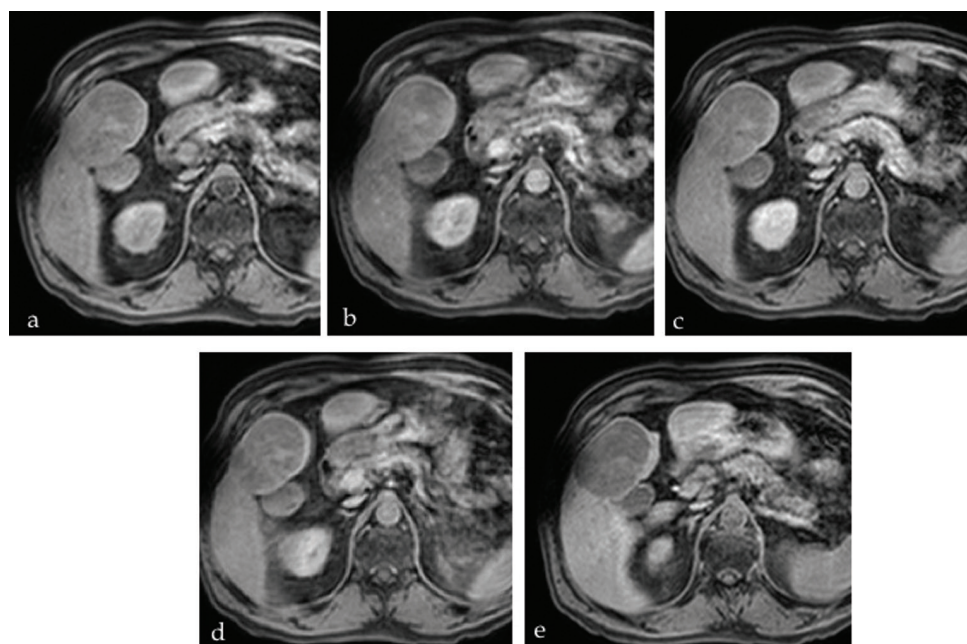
a–e. Hepatocellular adenoma on pre- and post-contrast T1W magnetic resonance imaging in multiple phases. This particular lesion is relatively hypovascular with mild inhomogeneous enhancement. There is an apparent capsule appearance.
